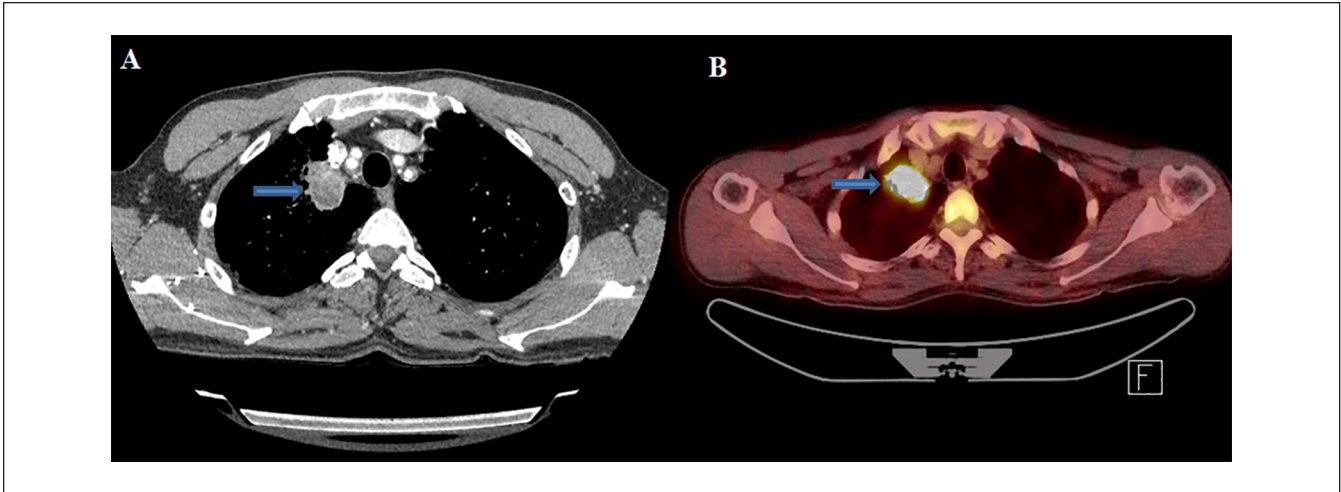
A preoperative chest computed tomography scan shows about 4-cm-sized mass with internal low attenuation and peripheral enhancement in right upper lobe apical segment (A, arrow). A positron emission tomography-computed tomography scan shows a well-defined lesion with intense fluorodeoxyglucose uptake in right upper lobe (B, arrow).
